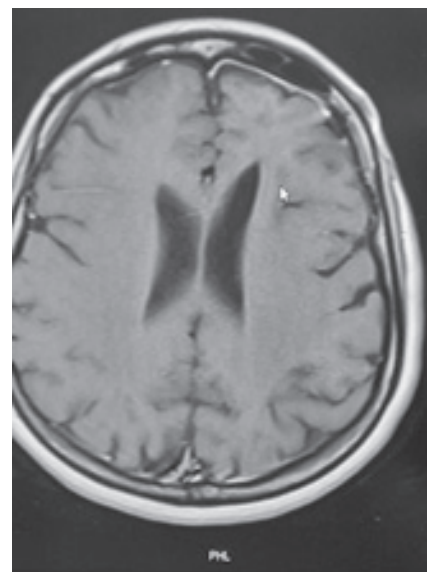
Shows the post-operative MRI.
